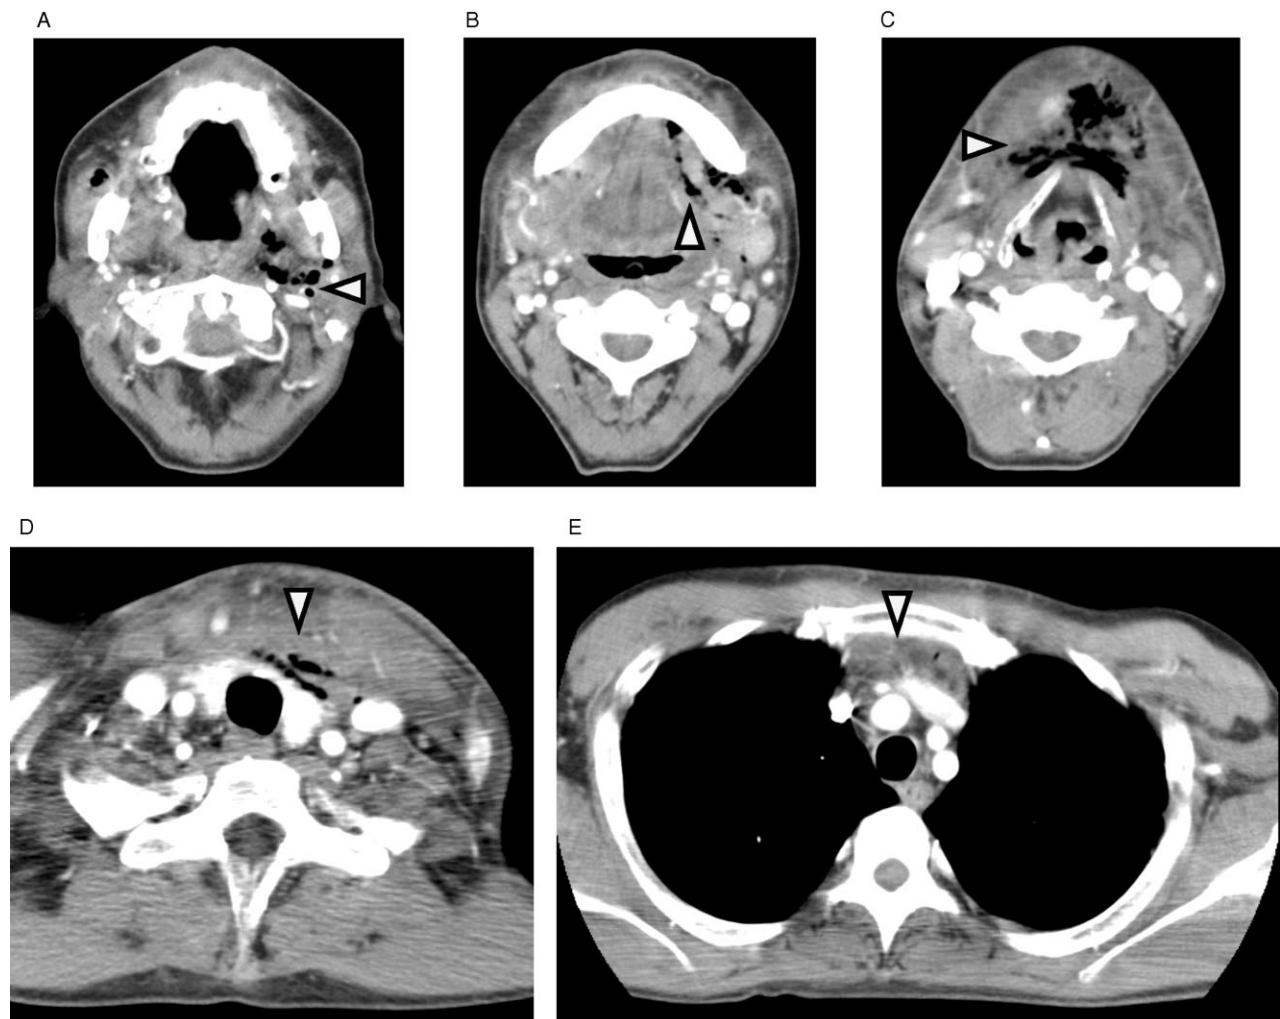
Contrast-enhanced computed tomography of neck and chest: anterior mediastinitis due to odontogenic source (reproduced from Sumi (2013),⁵³ “Current treatment for burn injury”). A, Gas collections in left masticator, parapharyngeal, and carotid spaces. B, C, Diffuse thickening of the subcutis, reticular enhancement of s.c. fat, and gas collections in submandibular space. D, Reticular enhancement of s.c. fat, and gas collections in pretracheal and anterior visceral space. E, Thickening and enhancement of anterior mediastinal fat and fluid collections.
